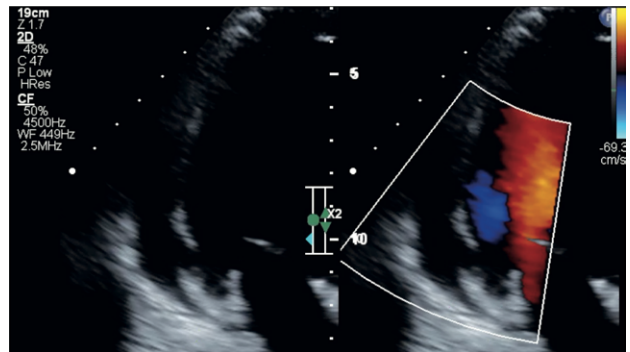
Transthoracic Doppler echocardiogram performed before patient discharge. No discontinuities on left ventricle wall or mitral valve regurgitation were found.
